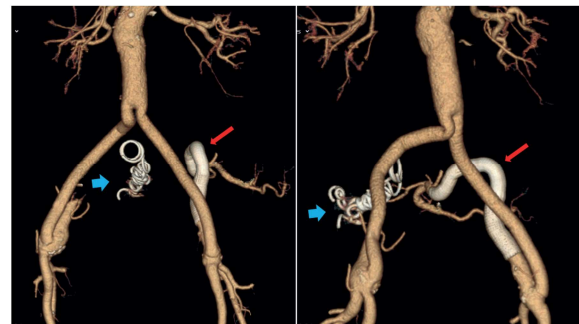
3D reconstruction of postoperative CTA.
